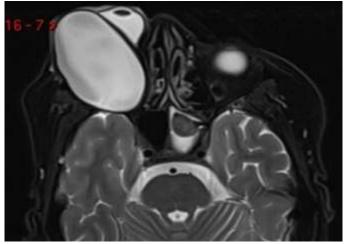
B: axial T2WI of MRI orbit, hyperintense lesion in intraconal compartment of right eye with mass effect upon underlying structures and significant proptosis.
